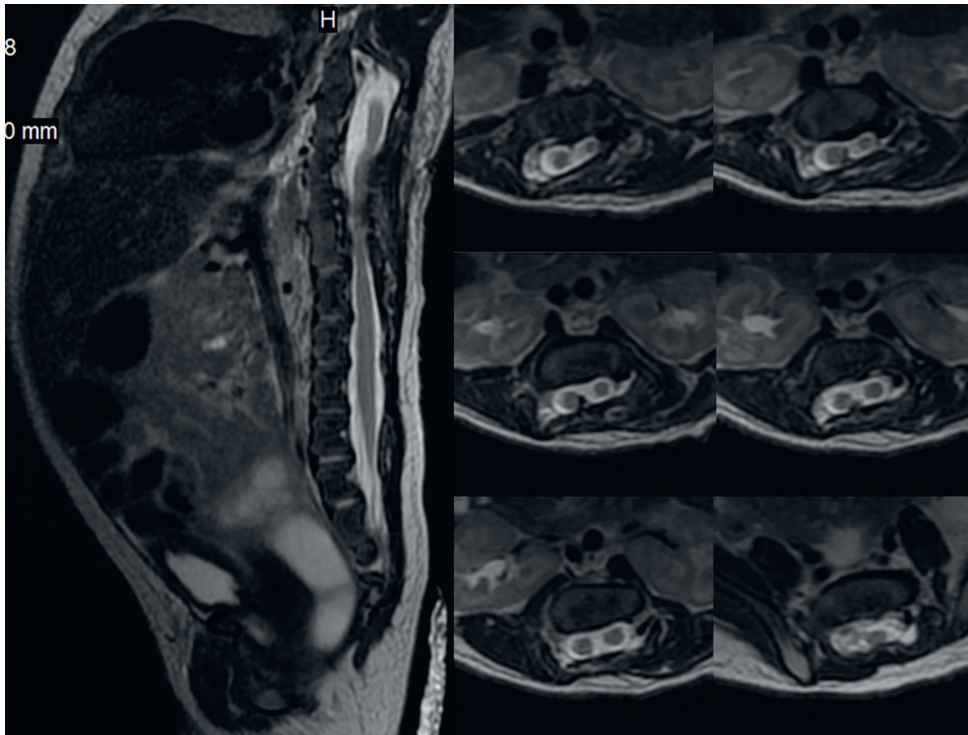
Female term neonate examined at the age of 7 days. FSE/T2-weighted images in sagittal A) and axial B) projection. Vertebral anomalies, tethered cord A) and diastematomyelia B) are observed
